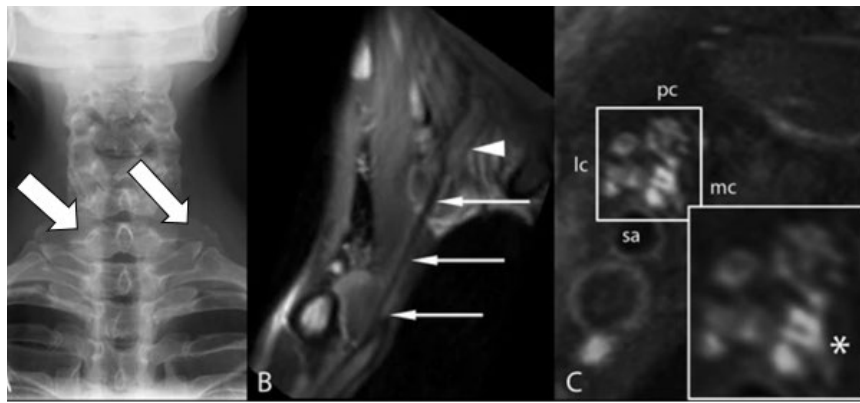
Diagnostic imaging findings for thoracic outlet syndrome: A) demonstrates a radiograph displaying bilateral cervical ribs (arrows); B) points out the fibrous band from the cervical rib to the first thoracic rib near the inferior trunk (arrows); and C) is a T2-weighted magnetic resonance image showing increased signal near the inferior trunk (asterisk). Reprinted with permission, with arrows added to the image in section A.¹⁰
